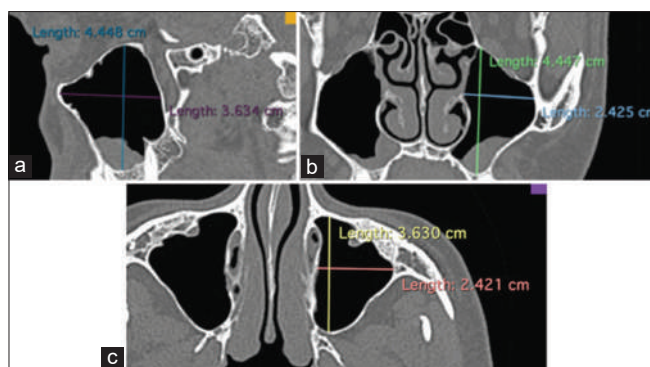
Left side MSV measurement on sagittal (a), coronal (b) and axial (c) CT images, CT: Computed tomography, MSV: Maxillary sinus volume
